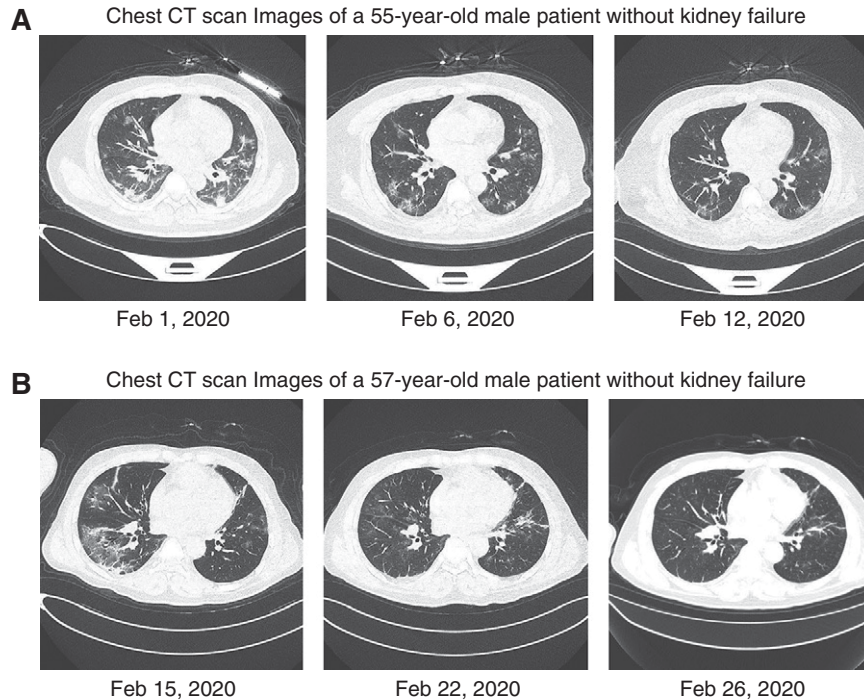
Chest CT scan images of two patients without kidney failure infected with severe acute respiratory syndrome coronavirus 2. (A) Bilateral consolidations and ground-glass opacities on admission. Bilateral consolidations being resolved in left and right lungs after 5 days. Further resolution of the lesions after 6 days. (B) Right-sided ground-glass opacities and consolidation and slight ground-glass opacities in left lung on admission. Resolution of the lesions in right lung and slight consolidation in left lung after 7 days. Further resolution of the lesions in right and left lungs after 4 days. Two patients were discharged.
